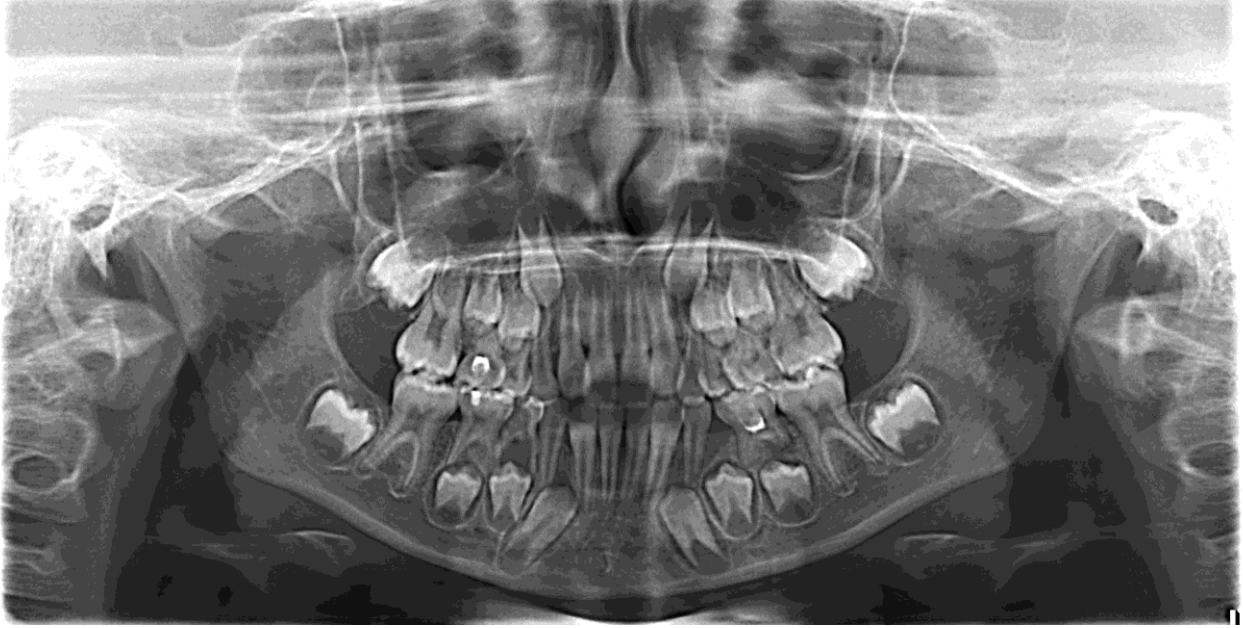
Panoramic X-ray picture at 8 years of age (mix dentition)
